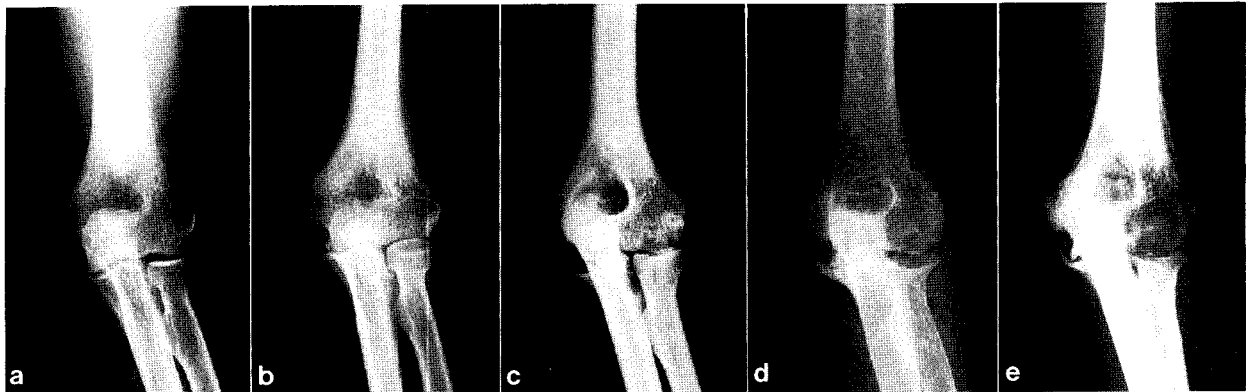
Antero-posterior X-rays of rheumatoid elbows used as standards for Larsen's X-ray evaluation. a: Grade 1; b: Grade 2; c: Grade 3; d: Grade 4; e: Grade 5.
